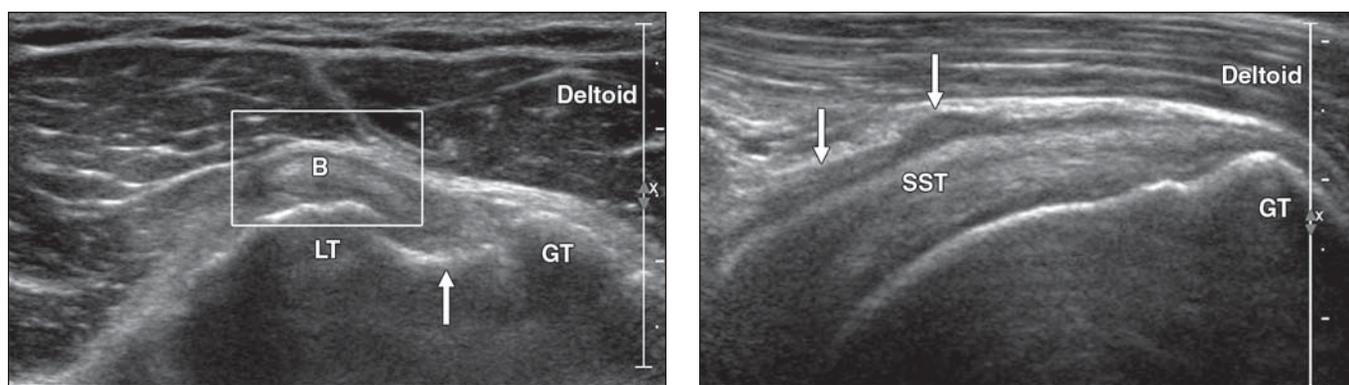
51-year-old man with asymptomatic medial subluxation of biceps brachii tendon. Short-axis ultrasound image of long head of biceps brachii tendon shows medial subluxation of biceps tendon (B) from bicipital groove (arrow) overlying lesser tuberosity (LT). GT = greater tuberosity.
